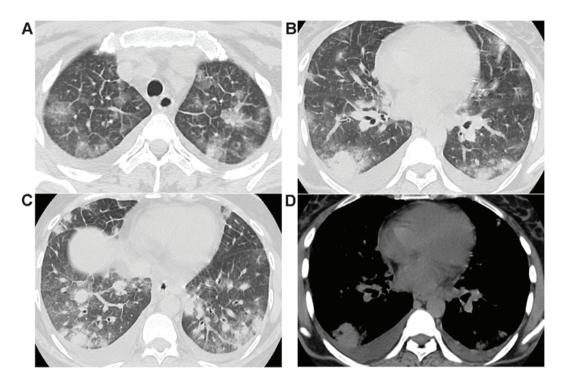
Chest CT revealed multiple bilateral pulmonary nodules with ground-glass opacities and pleural effusion.
